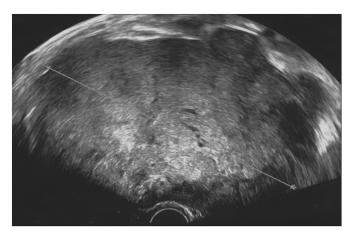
Ultrasound image with the solid tumor of the left ovary (6 in. diameter).
